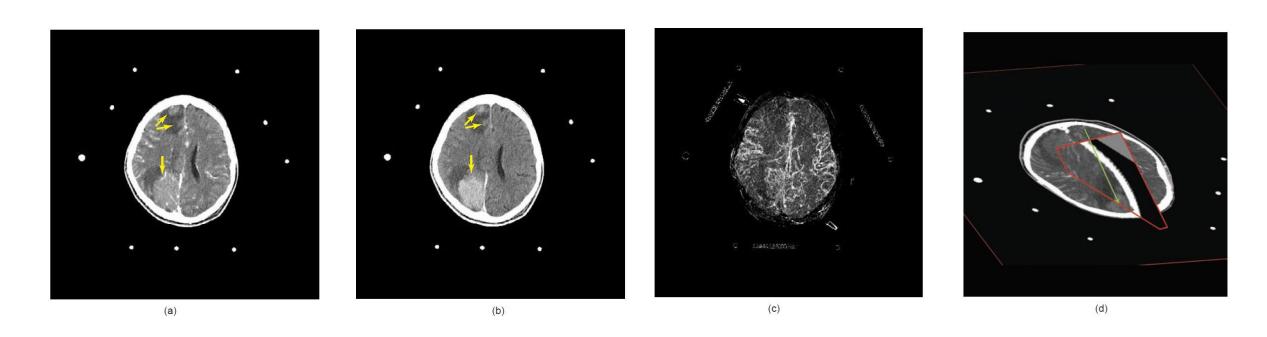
CT images through the brain used for neurosurgical planning. (a) CT slice immediately after contrast injection. The arrows show brain lesions surrounded by oedema. The nine bright spots around the patient are markers used for surgical planning. (More details are presented in Chapter 8.) (b) Late postcontrast image. After 10 minutes the tumoral lesions have absorbed the contrast and light up in the image. (c) By subtracting the CT images before and immediately after contrast injection, the cerebral blood vessels are visualized. In this image, the whole vessel tree is shown by a maximum intensity projection (MIP), explained in Chapter 4, p. 87. (d) All these images are used subsequently to calculate a safe trajectory (long arrow) through the blood vessels and toward one of the lesions in order to take a biopsy of the tumoral tissue. (Courtesy of Professor B. Nuttin, Department of Neurosurgery.)
